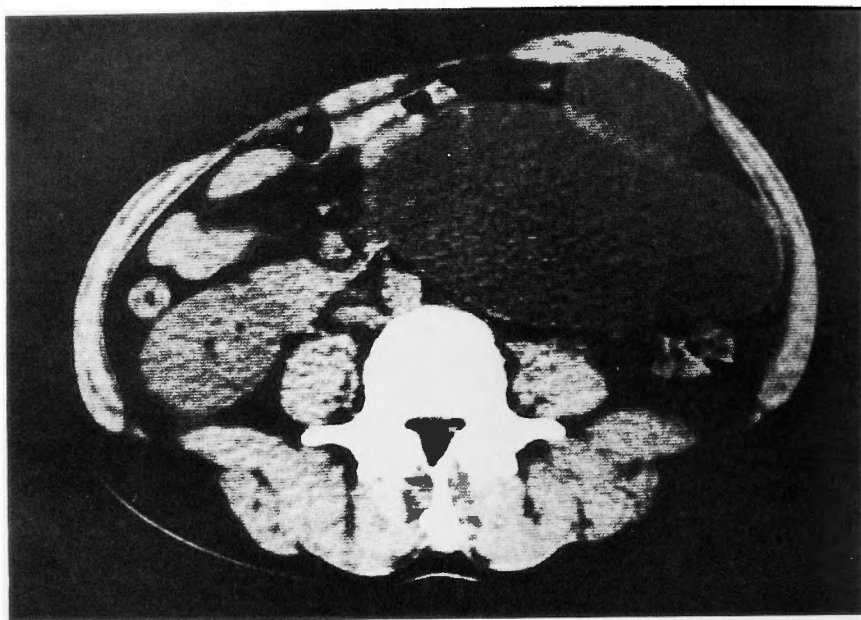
A CT scan suggesting a multilocular cystic mass originating from the pancreas.
